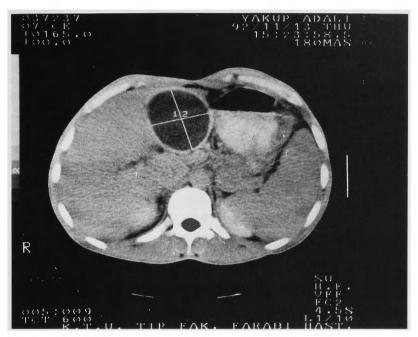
Hydatid cyst as a space occupying lesions in the right lobe of the liver by computed tomography.
